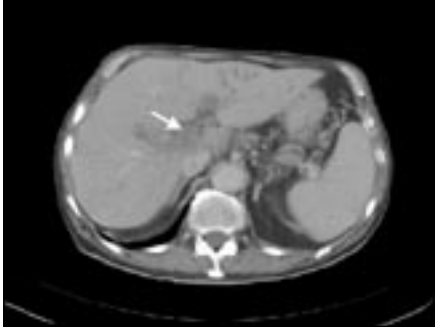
Abdominal CT scan (after intravenously administered contrast medium): thrombosis of the portal vein (arrow), slightly enlarged lymph nodes in the liver hilus, and extensive collaterals.
